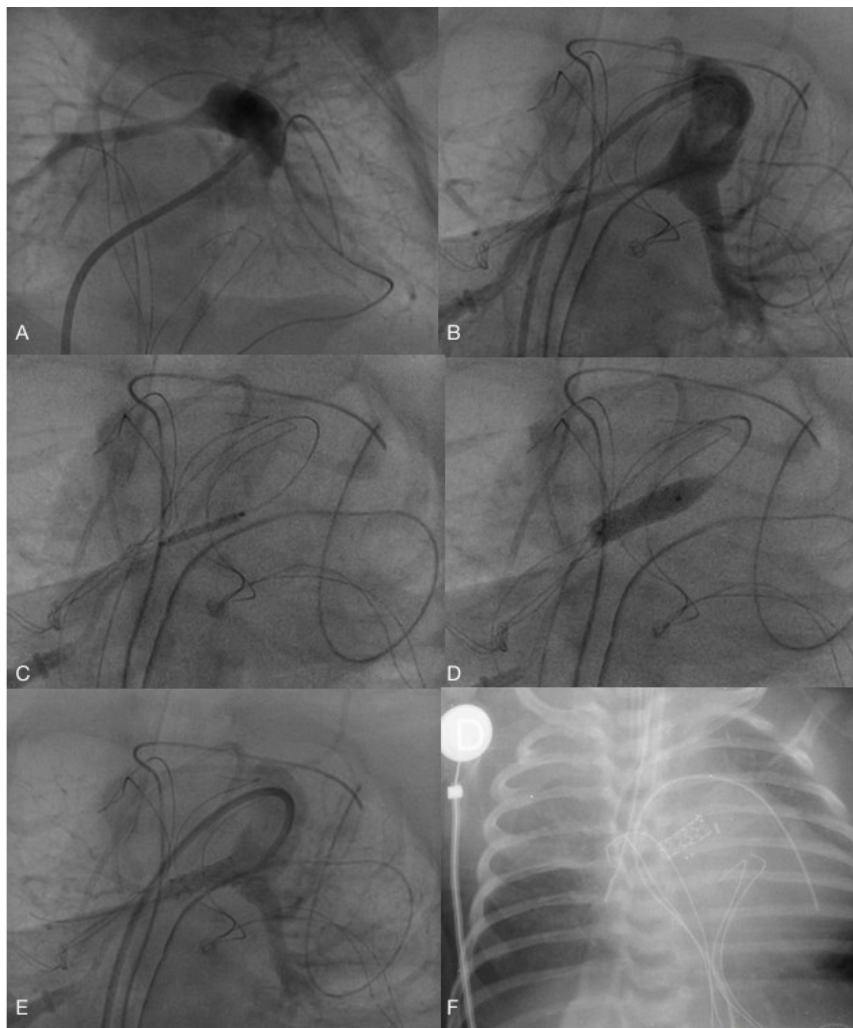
(A) Angiography in cranial position; (B) Angiography in caudal position; (C) Stent positioning; (D) Balloon dilation and stent implantation; (E) Control angiography same projection as image B; (F) Anteroposterior X-ray control.
